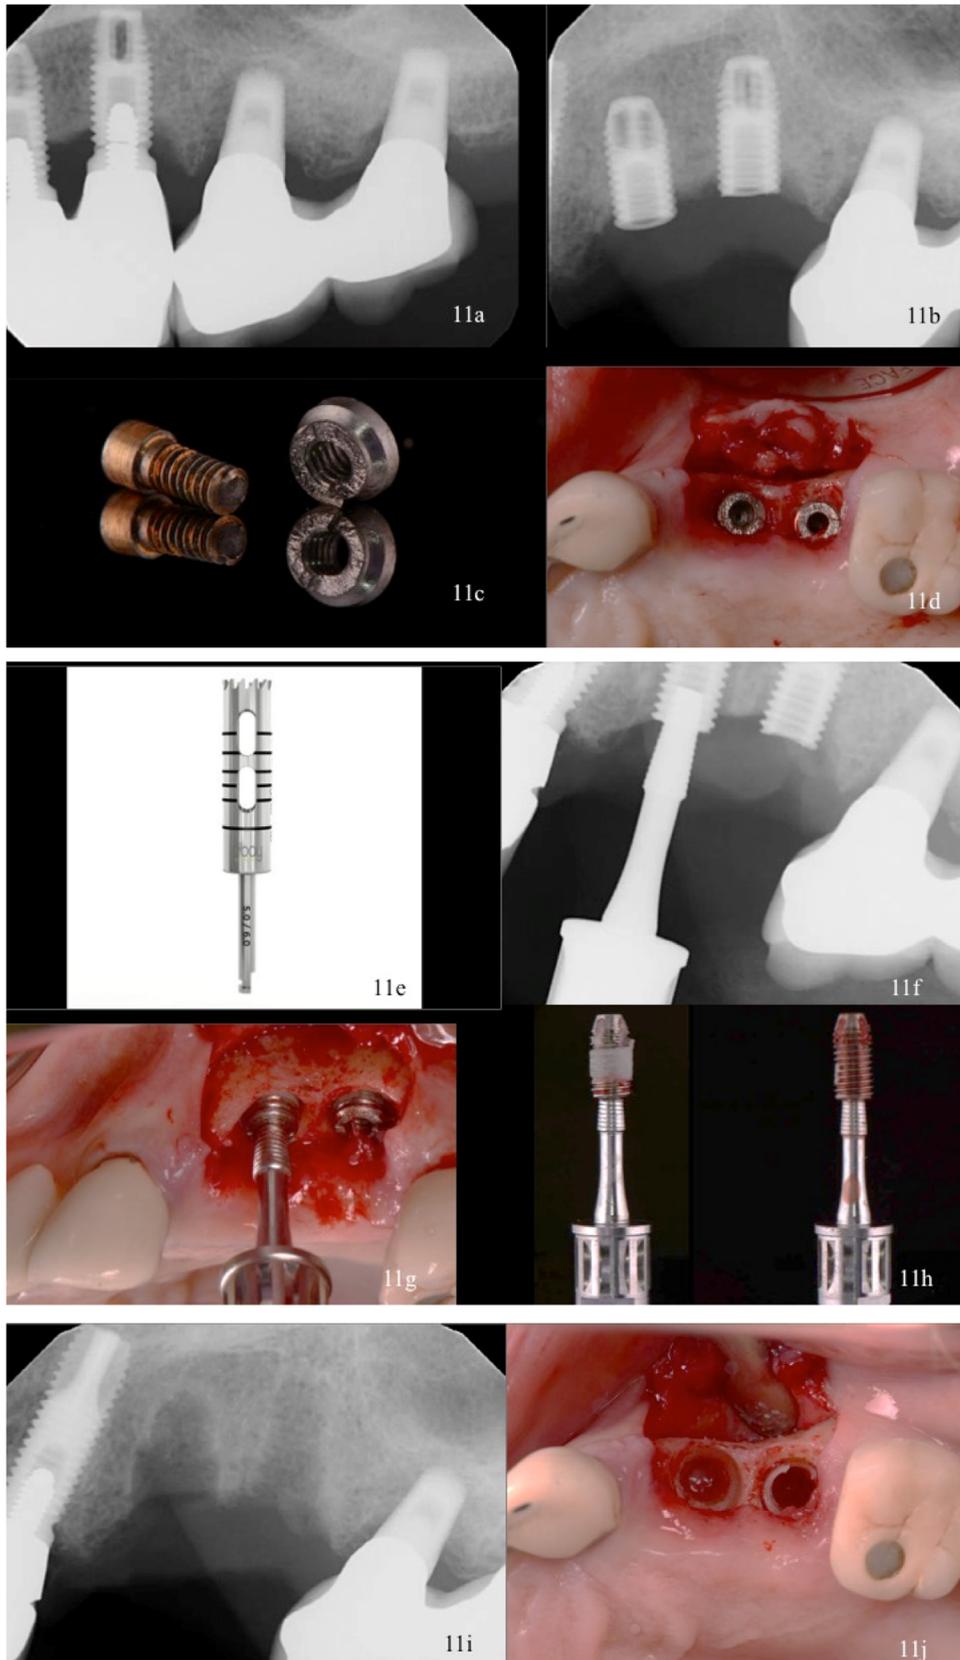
a. Periapical radiograph of two implants (maxillary left first and second premolars) with fractures below the implant-abutment connections. b. Periapical radiograph of the fractured implants with the prosthesis removed. c. Removed fractured head of the implant and the abutment screw. d. Intra-oral view of the fractured implants, note the bone surrounding the implants. e. Example of a trephine bur. f. Periapical radiograph showing the space created parallel to the coronal 1/2 of the implants by the trephine bur and a reverse screw device attached to the implant. g. A reverse screw device used to engage the implants and implants removed with a reverse torque wrench. h. Removed implants, note the bone attached to the implant at the trephined portion. i. Periapical radiograph after explantation, note the depth and size of the defect size. j. Intra-oral view of post-implant removal.
